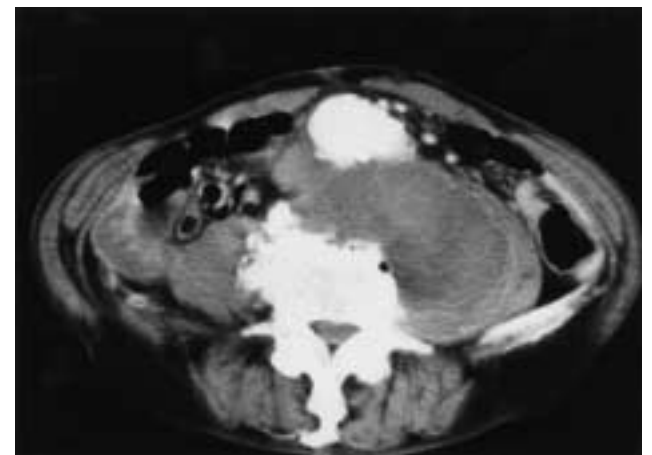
Abdominal CT scan of case 2 showing a left posterior aneurysm rupture.
